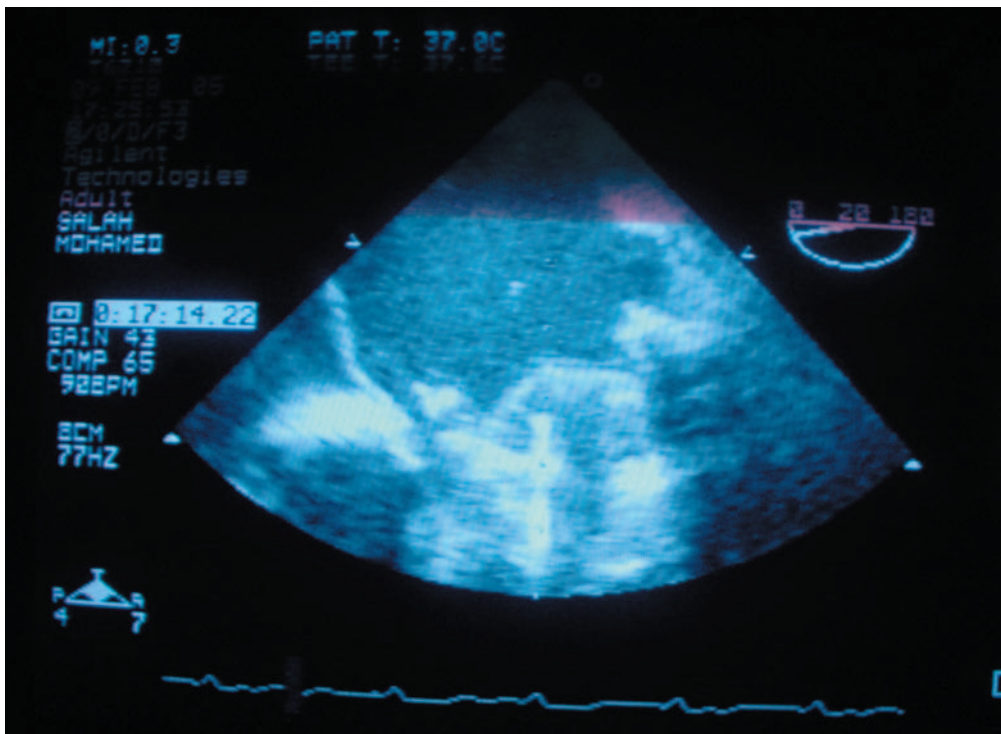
Intraoperative transesophageal echocardiogram showing both leaflets (arrow) of the prosthesis in the closed position.
